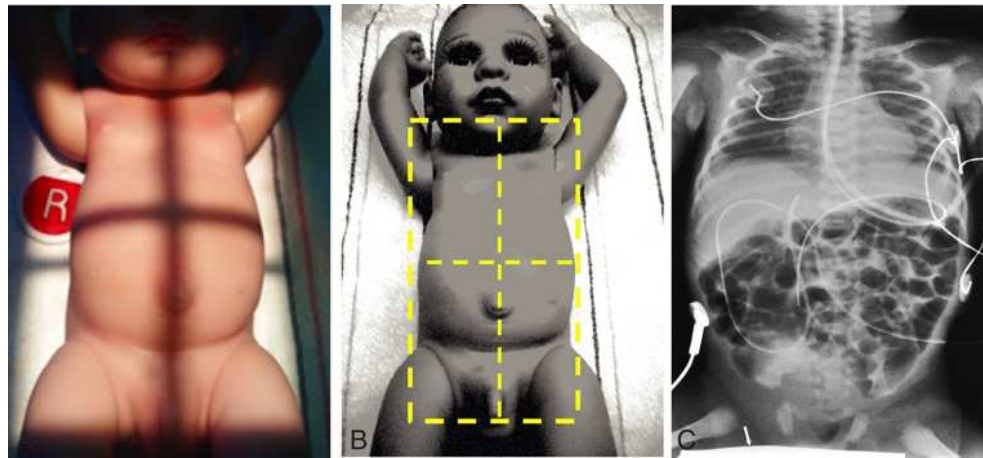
(A) Central ray directed to midpoint of chest and abdomen. (B) AP chest and abdomen, radiation light field. (C) AP chest and abdomen radiograph.
